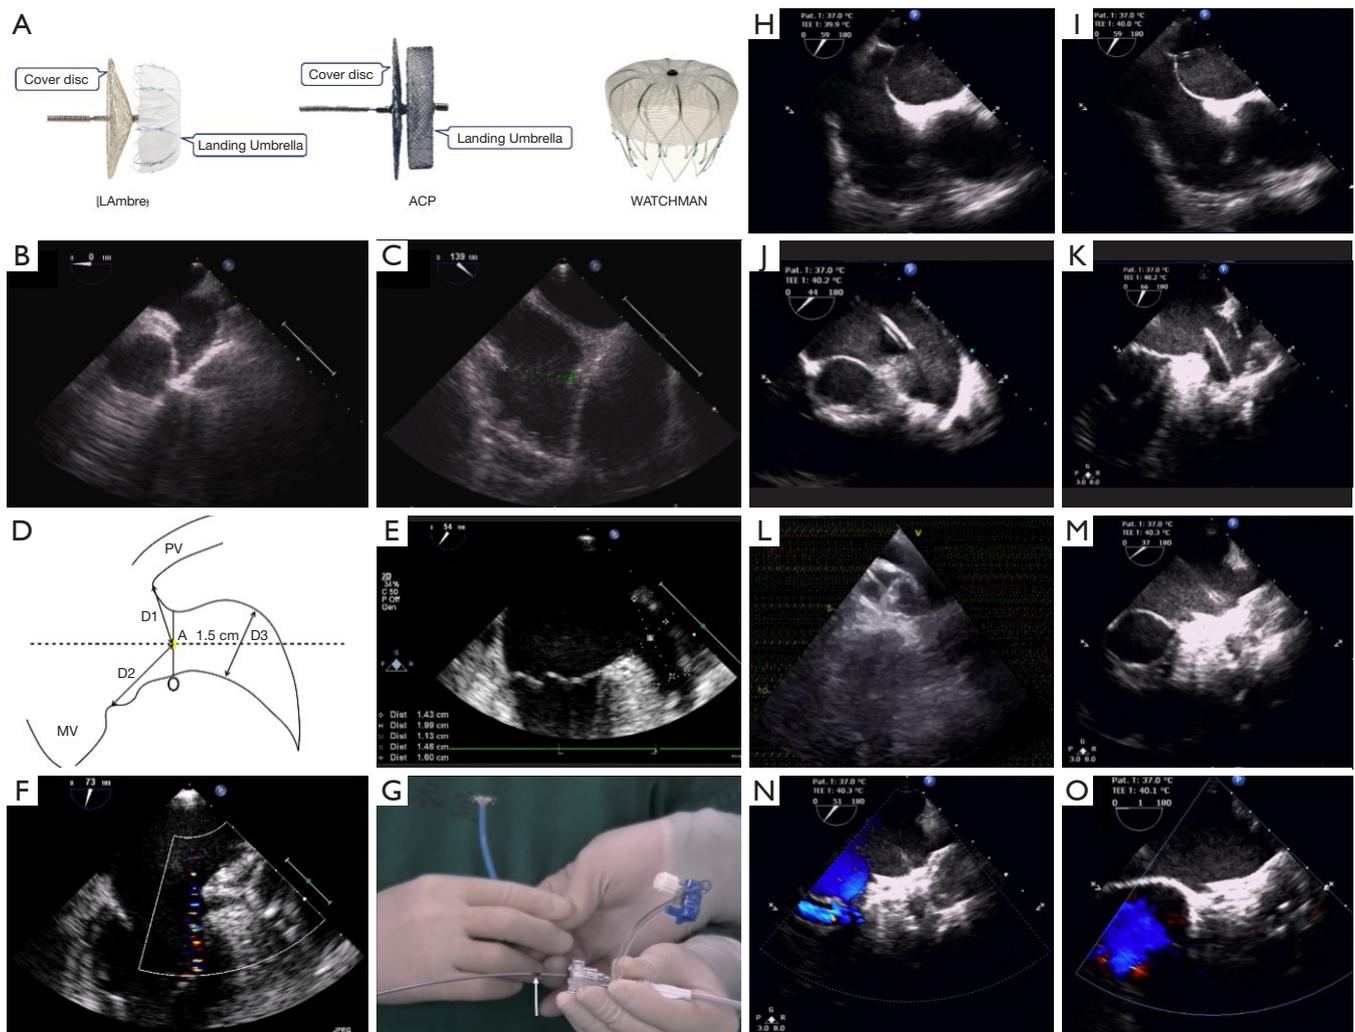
Structure of the LAA occluder (LAMBRE, ACP, and WATCHMAN) (A). TEE images of left atrium and left atrial appendage (B,C). Preprocedural imaging (D,E). Image of oversize occluder not being able to cover the left atrial appendage (F). The occluder being partly deployed out of the delivery sheath, with the delivery cable being marked with the arrow (\uparrow) (G). The atrial septum being punctured (H) and the puncture catheter being passed through the atrial septum into the left atrium (I). The pigtail catheter being advanced into the left atrium (J). The landing umbrella of the occluder being stretched out of the delivery sheath (K). The WATCHMAN occluder being deployed (L). The cover disc of the LAMBRE occluder being sequentially stretched out (M). The occluder being implanted without residual leakage as per Doppler ultrasound (N). The occluder being completely released (O). ACP, Amplatzer Cardiac Plug; PV, pulmonary vein; MV, mitral valve; D1, the distance between the left lower PV; D2, the mitral annulus; D3, distance of 1.5 cm from point A; LAA, left atrial appendage; TEE, transesophageal echocardiography.
